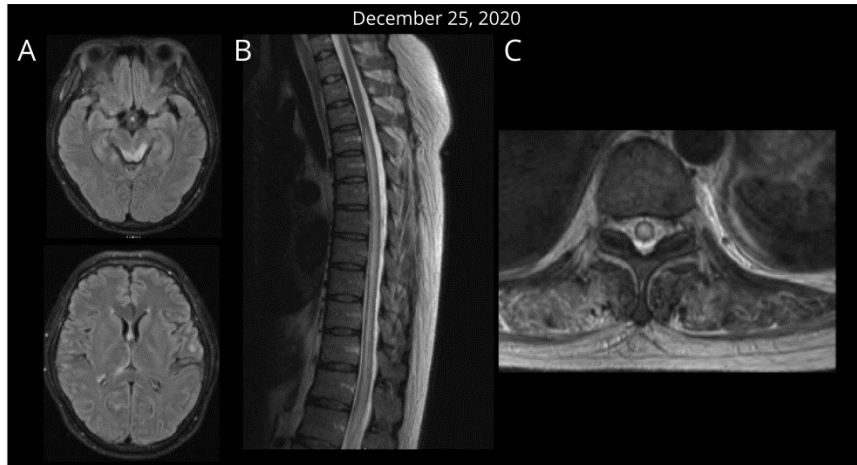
MRI (C-) Full resolution of the diffuse inflammatory encephalomyelitis (LETM) in a repeat MRI (C-) 10 months and 19 days after initial presentation. (Normal axial view of the brain (A), normal sagittal view of the spine (B), and normal axial view of the spine (C))
